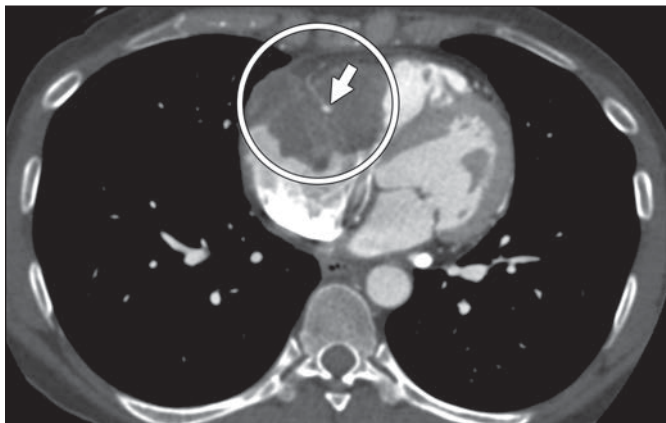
Search error and framing bias. Clinicians reported high suspicion for pulmonary embolism (PE) in 40-year-old woman with history of cervical cancer and shortness of breath. CT scan was interpreted as negative for PE overlooking intracardiac metastasis (*circle*) crossing between right atrium and ventricle. Note right coronary artery in right atrioventricular groove (*arrow*). Framing bias may have played role in this case because radiologist framed their interpretation around concern for PE.
